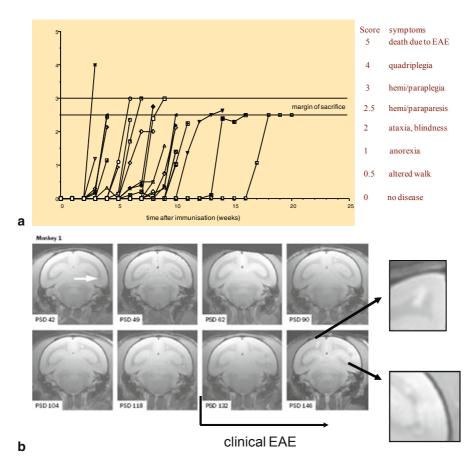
Clinical and pathological development of the rhMOG/CFA EAE model. a A single immunization with 100  $\mu$ g rhMOG in CFA suffices to induce clinical EAE in marmosets from an outbred population. The model is characterized by a 100% incidence but variable time of onset. b Serial MRI (T2-weighted) shows that already after 6 weeks a white matter lesion is detectable whereas neurological deficits can be first observed about 3 months later. Around the presence of clinically evident EAE, spreading of lesions to the cortical gray matter can be found (*inserts*). The early and late phases of the disease in this model are likely driven by the two distinct pathogenic mechanisms depicted in Fig. 14.3
